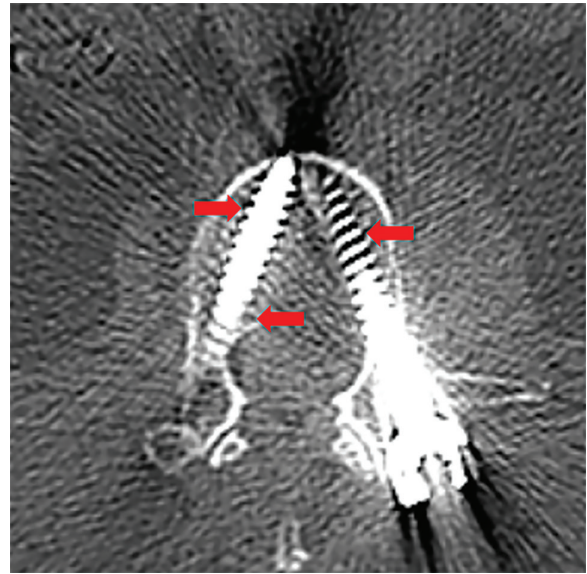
Six months after surgery, osteointegration of the screws to the bone was observed on computed tomography images. In the entire vertebral body, the bone tissue was observed to be populated between the screw threads (red arrows).
